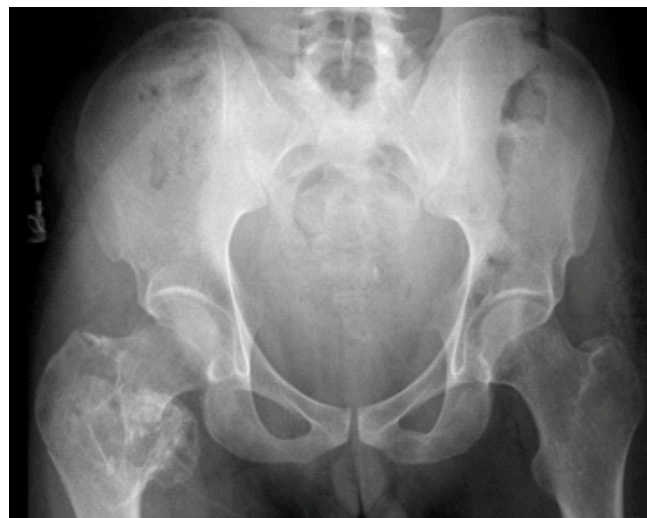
Pelvic radiograph showing right proximal femur lesion 6 years prior to the current presentation.
